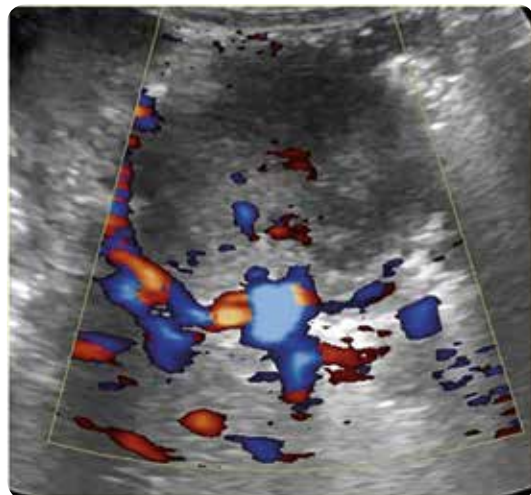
Ultrasound of the total abdomen, grey scale, mode B. Mass probably dependent on the left adrenal gland, solid aspect, heterogeneous echogenicity, defined contours, with flow of peripheral predominance after the application of color Doppler.
